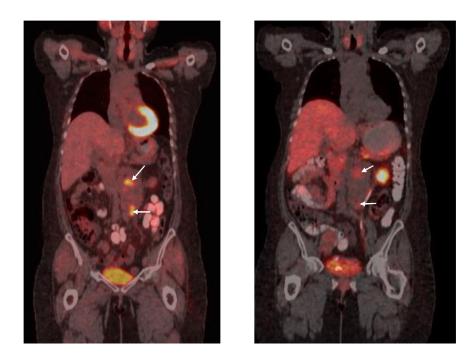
(A) Whole body F18-FDG PET/CT showed metabolic activity of the left para-aortic mass. (B) Whole body Ga68 DOTA TOC PET/CT showed less metabolic activity in comparison to the F18-FDG PET/CT scan.
